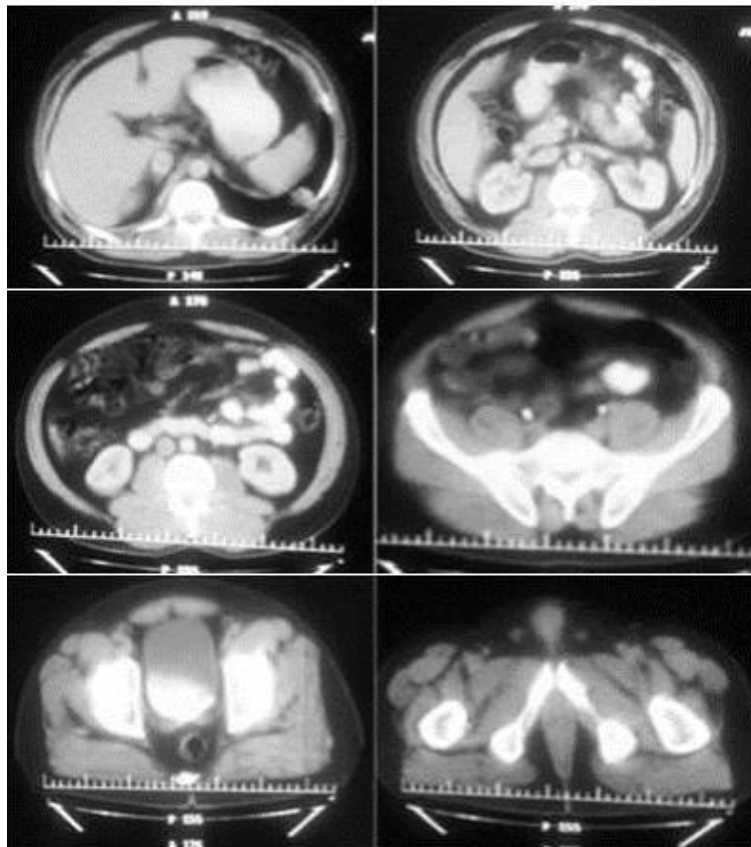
Abdominal-pelvic CT scan: no evidence of neoplastic or inflammatory lesions of the abdominal-pelvic viscera
